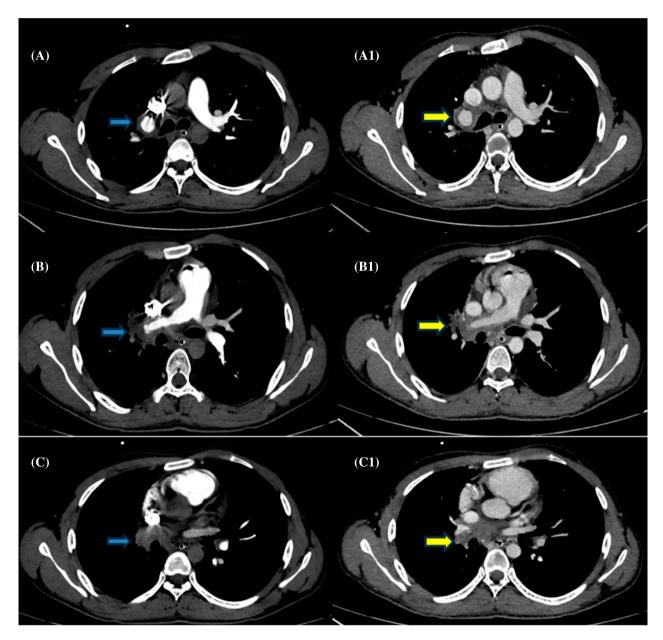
Axial computed tomography images in pulmonary arterial phase (left column) and venous phase (right column) at different sections showing eccentric filling defect suggestive of thrombus in the right pulmonary artery (blue arrow) with mural enhancement seen on the venous phase (yellow arrow).
